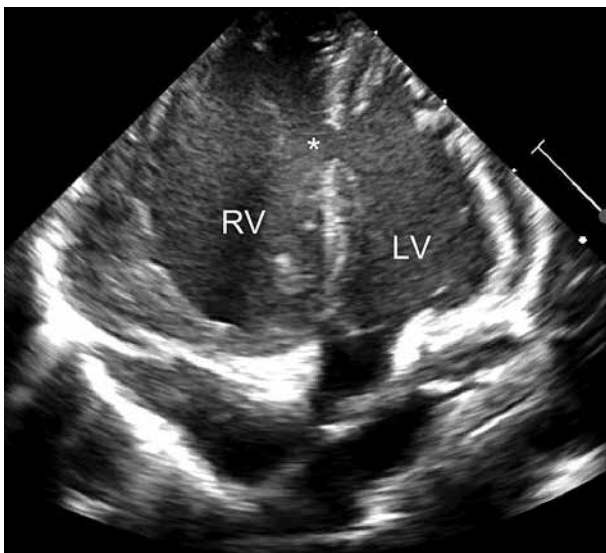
Epicardial echocardiography. Ventricular septal defect (VSD) – asterisk
